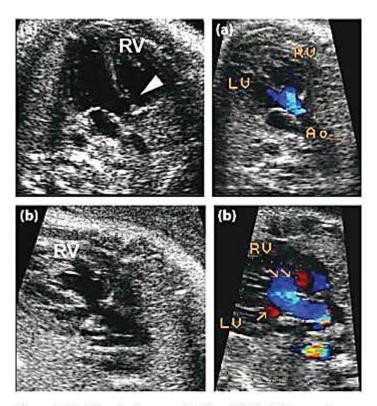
Figure Ventricular septal defect (VSD). VSDs not detectable on the four-chamber view but only on the left outflow tract view which include (a) outlet subaortic perimembranous VSD (color Doppler demonstration on the right, 31 weeks of gestation); and (b) malalignment VSD, with the ascending aorta overriding the VSD (color Doppler demonstration on the right, 27 weeks of gestation). Ao: aorta; LV: left ventricle; RV: right ventricle.
